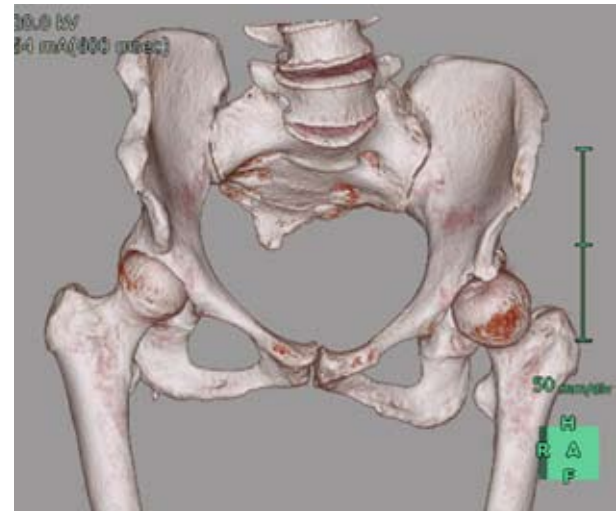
Hypoplasia of the left hip acetabulum in 3D CT
